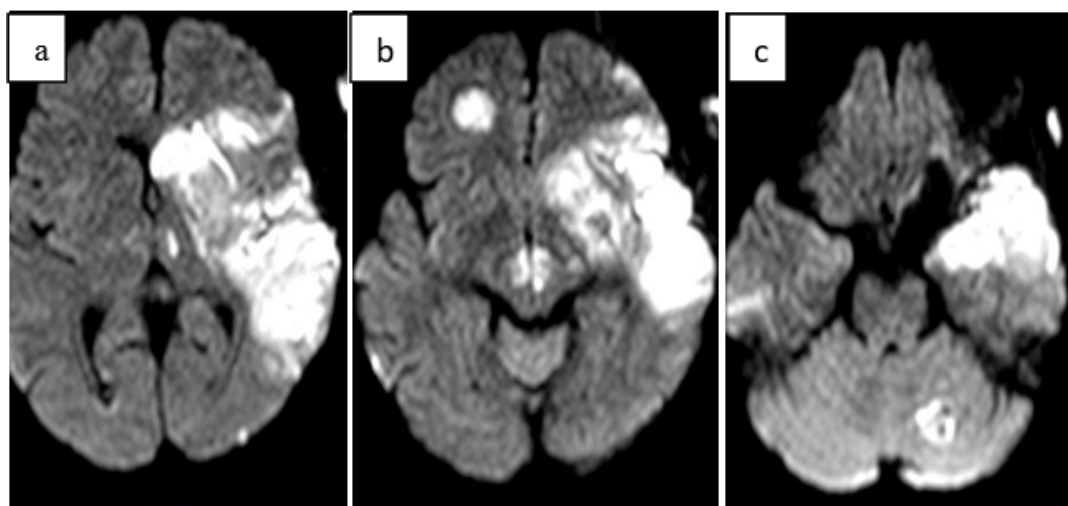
a: MRI brain DWI showing extensive infarct involving left basal ganglia, fronto temporo parietal region; b: MRI brain DWI showing infarct seen in right frontal lobe and bilateral thalamus and hypothalamus, c: MRI brain DWI showing infarct seen in left cerebellum and left temporal lobe
